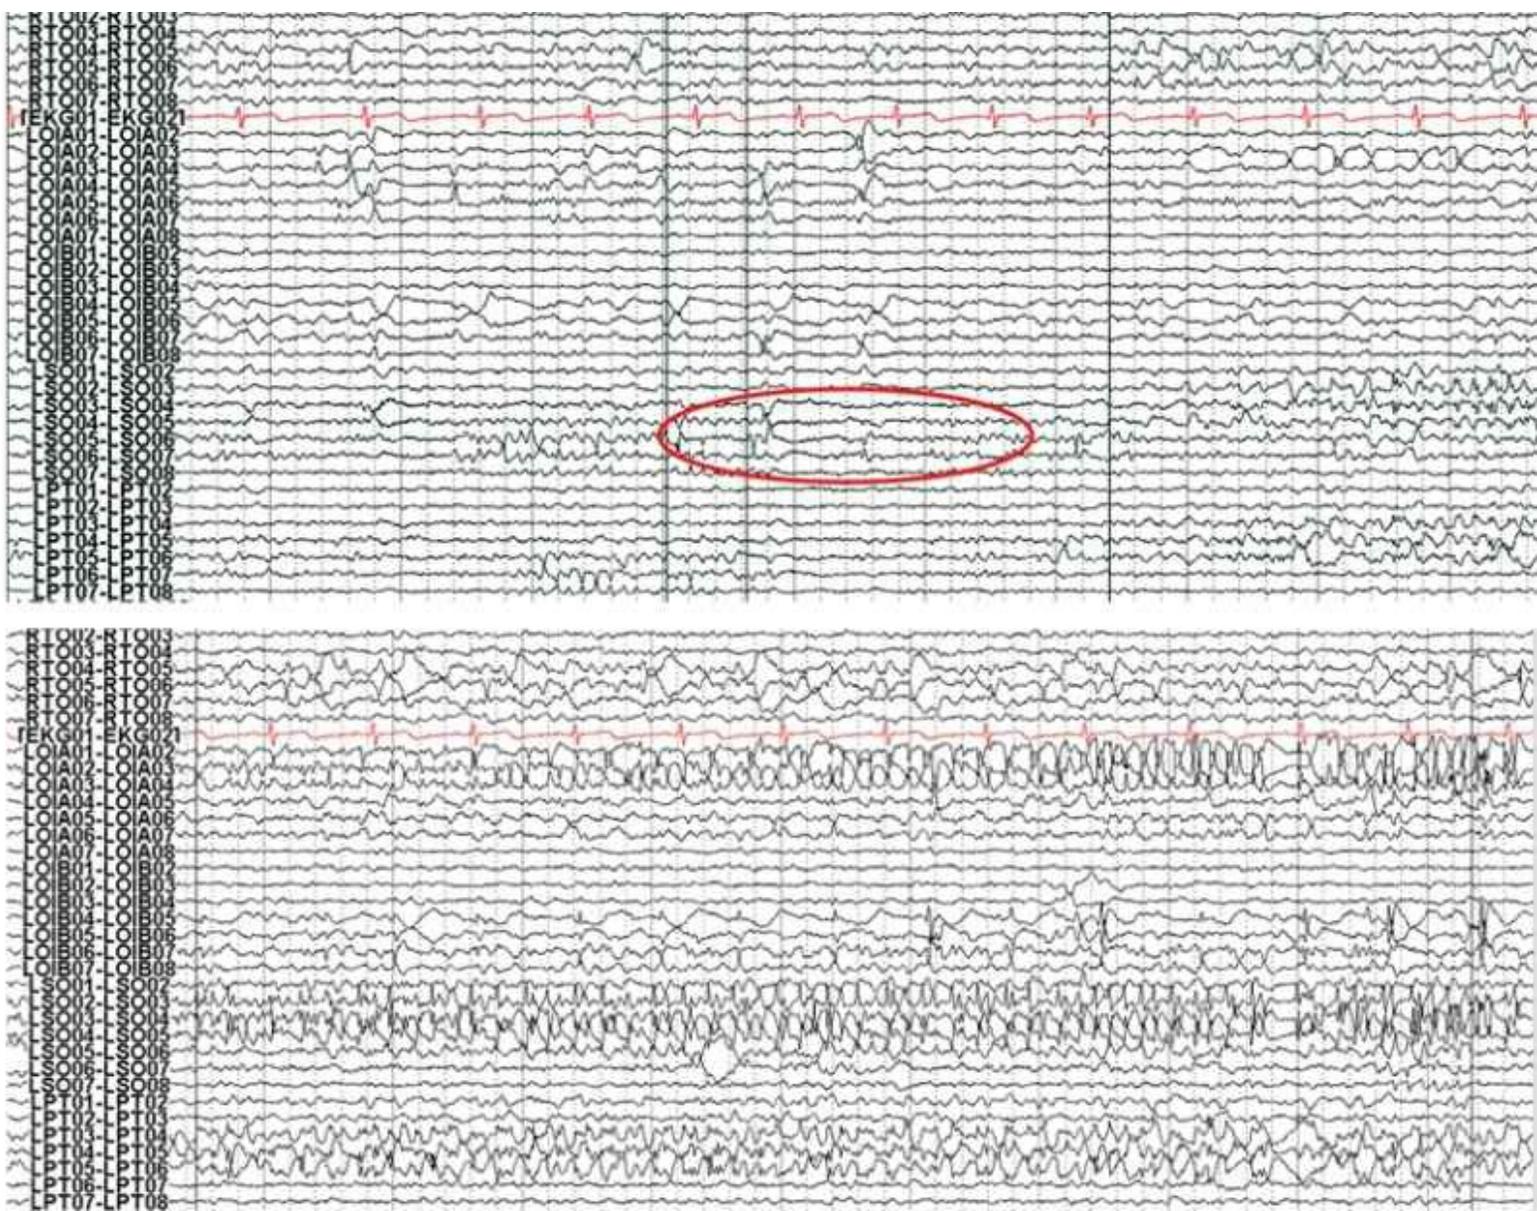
Occipital lobe epilepsy in a 15-year-old boy who had medically refractory complex partial seizures with an aura of flashing lights in the right visual field, progressing to oral automatisms and loss of awareness. A and B: Development of the left occipital discharge on surface EEG. C: 3D MRI rendering and skull x-rays showing the coverage of all three occipital surfaces with subdural strip electrodes. D and E: Cortical map with seizure onset at visual evoked responses shown. F: Intracranial recording demonstrating left inferior occipital onset of gamma.
